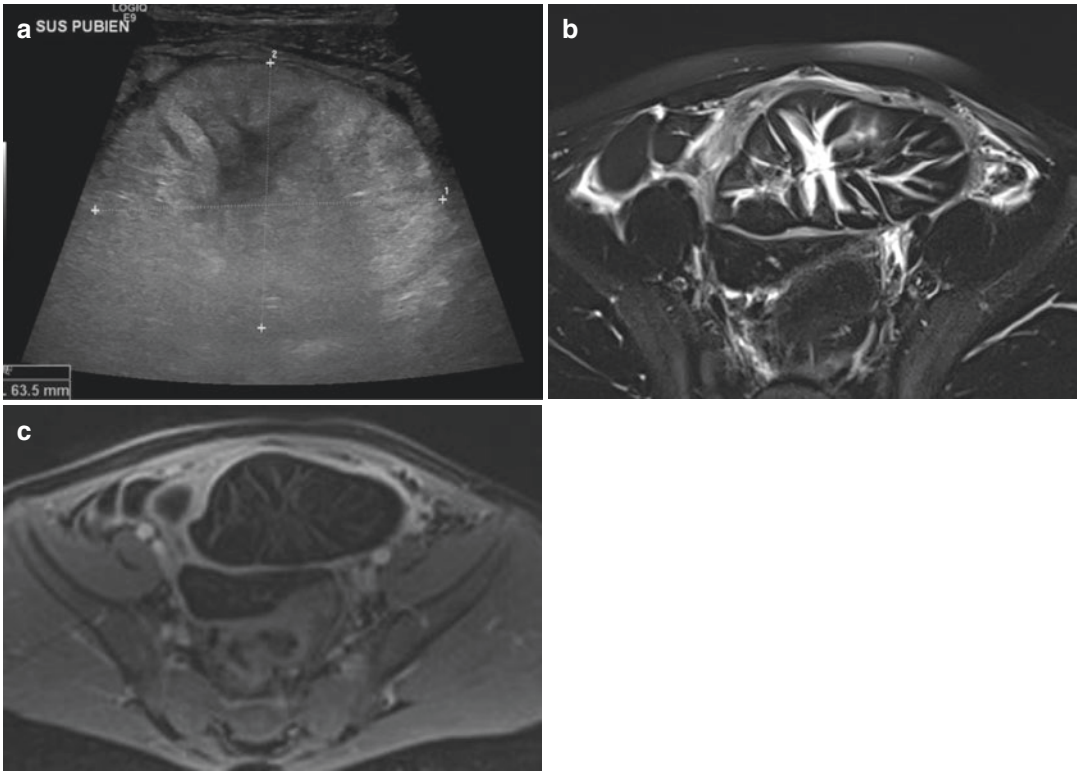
Torsion of the greater omentum secondary to a giant lipoma (6-year-old boy). (a) US: A large (8 × 7 cm) echogenic mass occupies the pelvis. (b) MR imaging axial T2-weighted fat-sat confirming the fat content of the mass. (c) MR imaging axial T1 after Gd enhancement; lack of enhancement of the mass; an enhancement of the capsule is preserved
